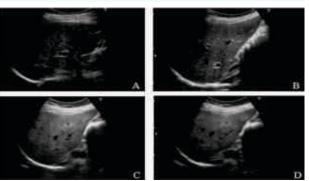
Liver Ultra-Sonographic Images showing the Comparison between the Normal Liver of Male and Female Gender (A, B) with the NAFLD Male and Female Liver (C, D).*
